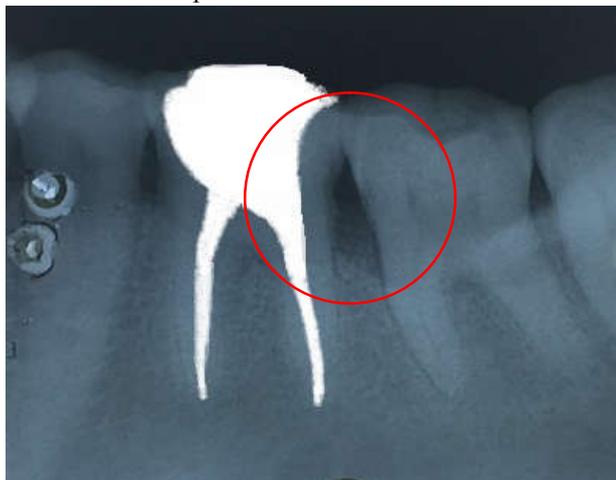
Radiograph showing vertical bone loss
